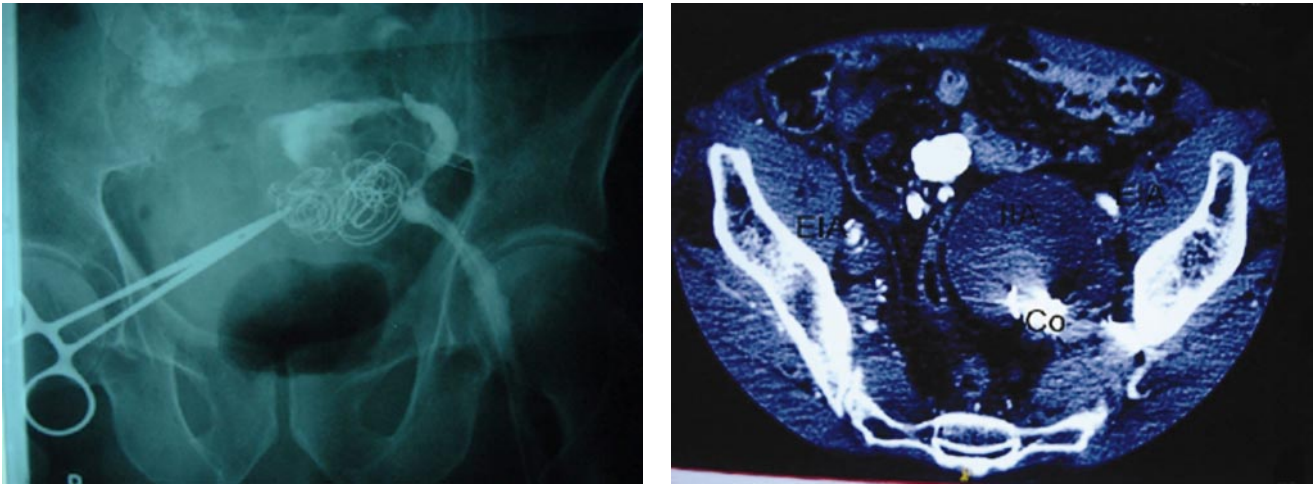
CT scan showing contrast in external iliac arteries (EIA), but not in occluded internal iliac aneurysm (IIA). Coils (Co).
